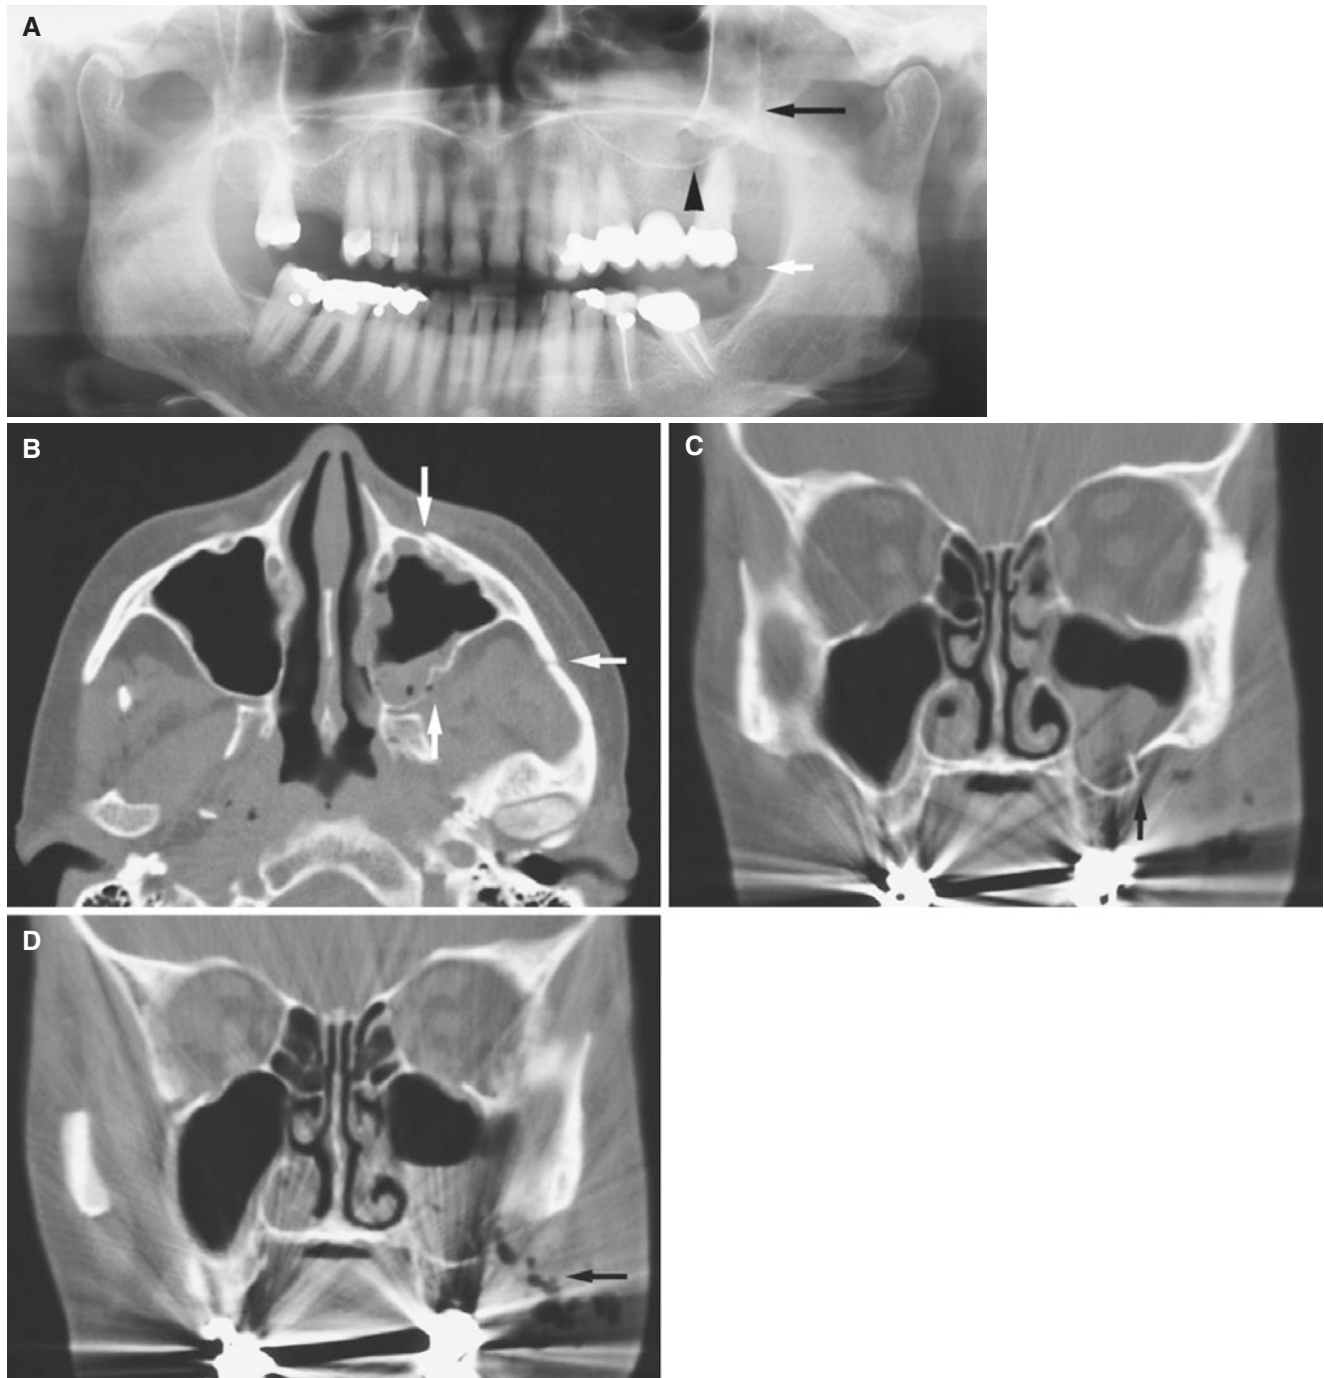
Tripod fracture, but no evident lateral orbital wall fracture; 70-year-old female with trauma to face 3 days previously. (A) Panoramic view shows opacification of the left maxillary sinus (*arrow*) with abnormal structure (*arrow head*) and possibly some air collections (*white arrow*). (B) Axial CT image shows fractures of anterior maxillary sinus wall, lateral-posterior maxillary sinus wall, and zygomatic
